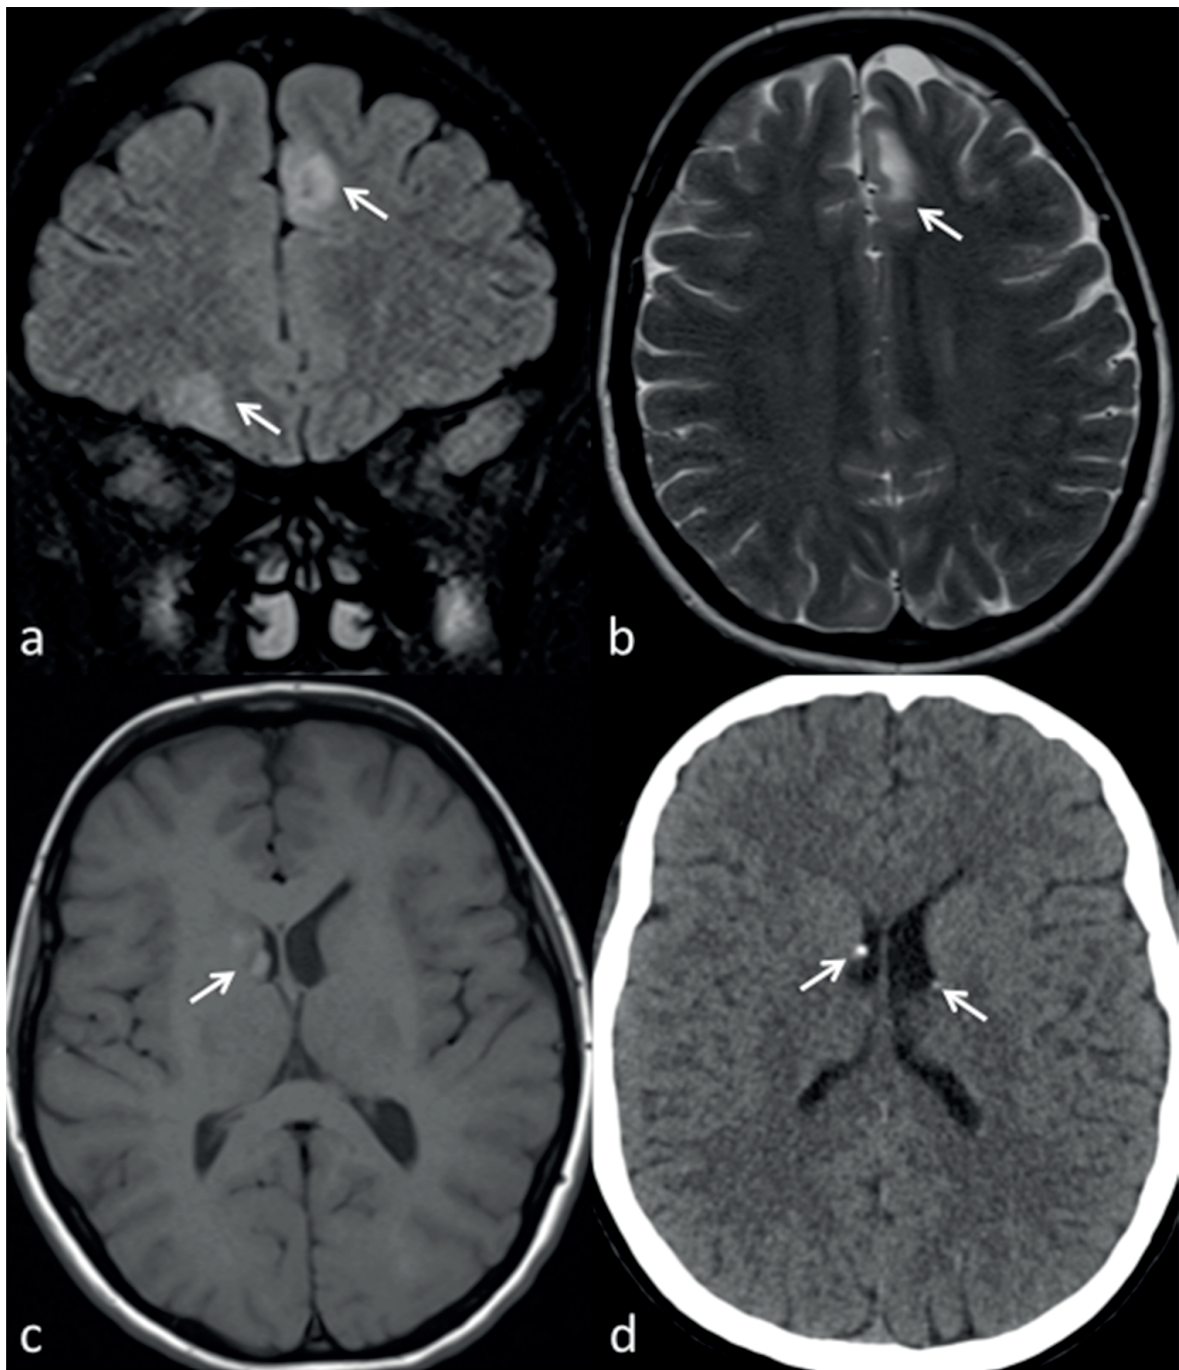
(a) T2-weighted coronal FLAIR and (b) T2W axial MRI sequences demonstrate hyperintense cortical tubers (arrows) (c) T1W axial MRI image shows the subcortical, hyperintense subependymal nodule adjacent to the foramen Monro (arrow) (d) Axial computed tomography section shows subependymal calcified nodules (arrows).
